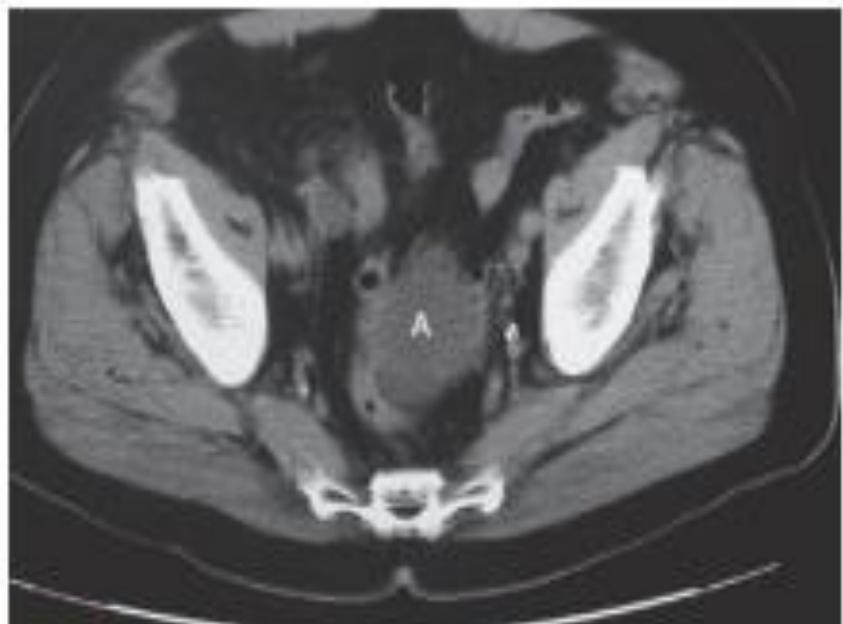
Computed tomogram of the pelvis. A, Diverticular abscess.
